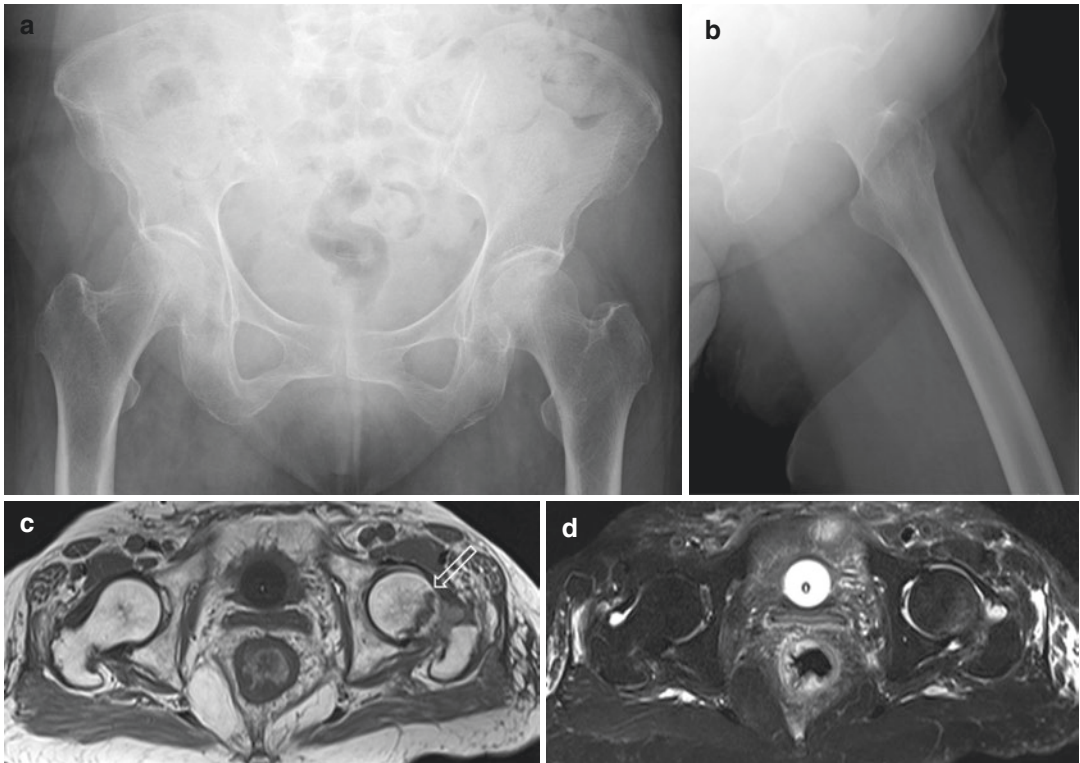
An 83-year-old woman who presented with left hip pain after a fall. (a) Frontal radiograph of the pelvis and (b) lateral radiograph of the left hip show no appreciable fracture or dislocation. There is diffuse reduction in bone density, which limits radiographic sensitivity for minimally displaced fractures. (c) Axial T1-W MR image
